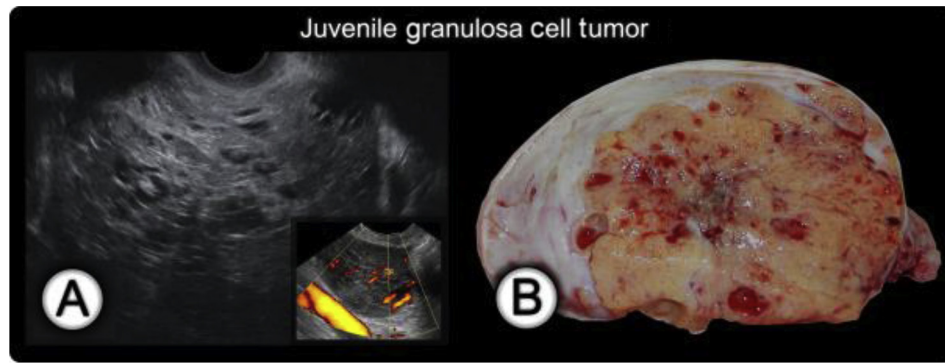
Juvenile GCT of the right ovary. (A) An ultrasound transvaginal scan of characteristic “sponge-like” appearance of multilocular-solid tumor with innumerable cystic spaces filled with low-level fluid (i.e., blood). Increased vascularity in solid portion of tumor is demonstrated on power Doppler; (B) gross tumor appearance with multiple blood-filled cysts within the tumor. The solid component is typically yellow-tan. GCT = granulosa cell tumor.
